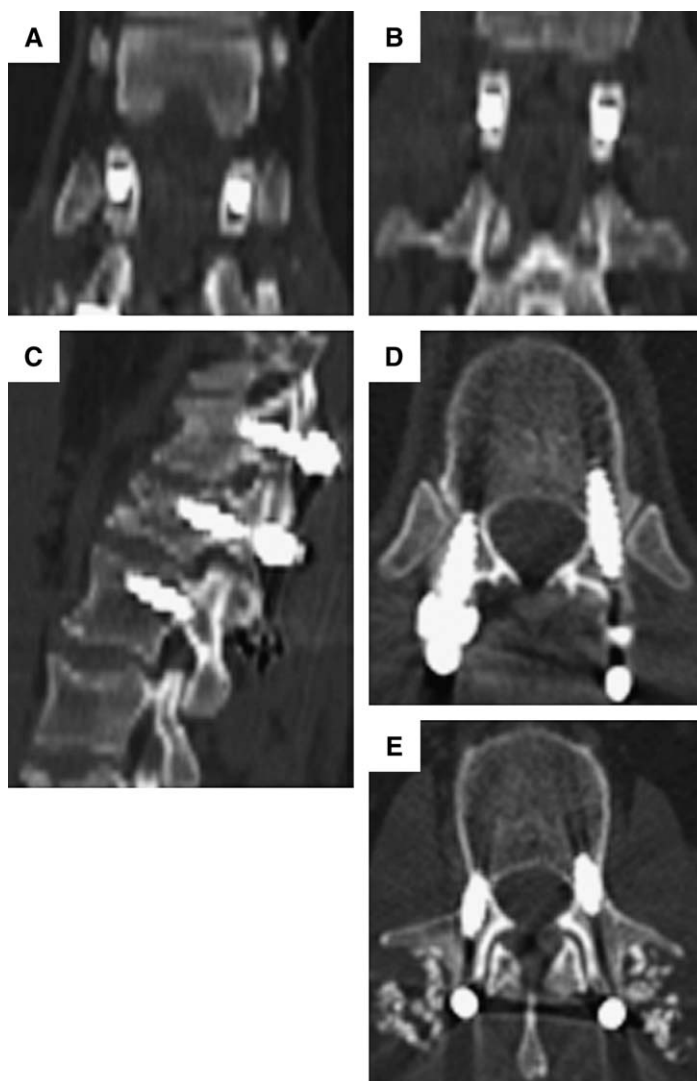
Postoperative reconstructed CT scan images demonstrate the potential accuracy of percutaneous spinal instrumentation in the thoracic and lumbar spine as revealed in postoperative coronal (*A*, *B*), sagittal (*C*), and axial (*D*, *E*) CT scan images.
